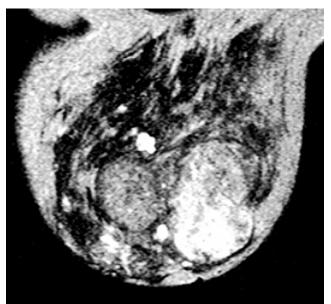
MRI of the breast showing a bilobed area of angiogenesis. One of the lobes shows very little angiogenesis.
